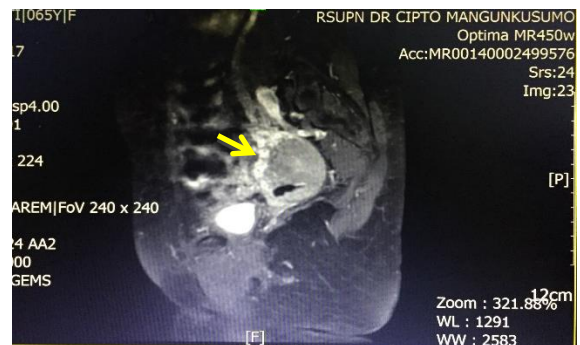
MRI finding: fat stranding covering the lesion (yellow arrow)
